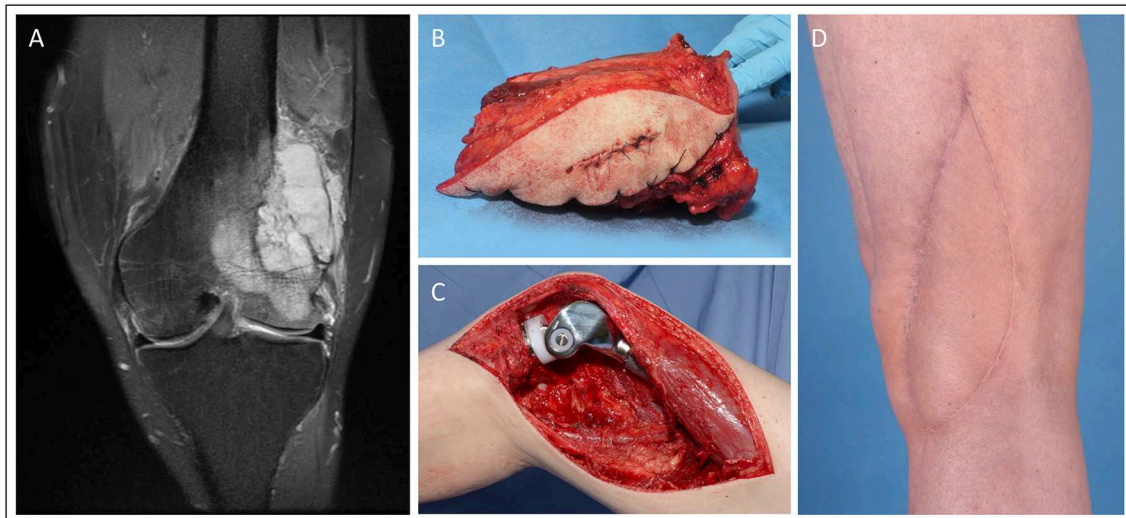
Knee reconstruction with tumor prosthesis and microsurgical soft tissue coverage in a patient presenting with femur-infiltrating leiomyosarcoma. (A) Pre-OP MRI of the left knee (B) Resected distal femur with tumor free margins (C) Intraoperative situation with implanted modular tumor prosthesis after tumor resection. (D) Post-operative esthetic outcome in the 6 months follow-up.
